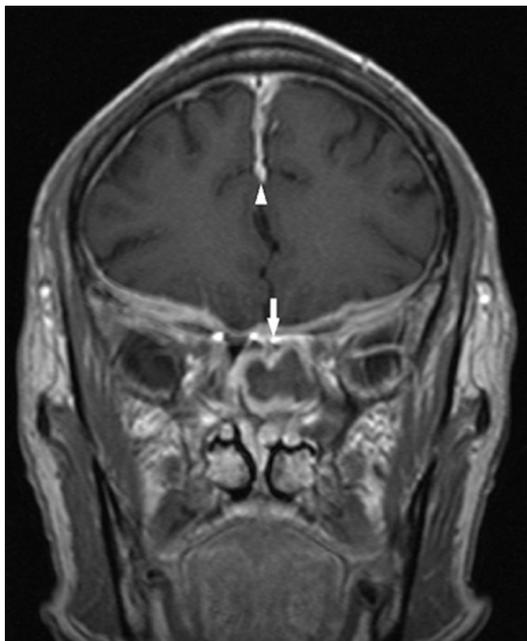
Preoperatively, contrast-enhanced, coronal T1-weighted brain magnetic resonance imaging revealed leptomeningitis involving the cavernous sinus (arrow) and cerebral falx (arrow head).
